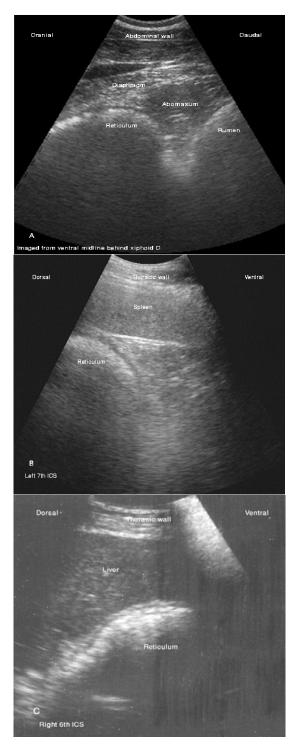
Sonogram of normal buffalo's reticulum with its relation to adjacent abdominal organs (rumen, abomasum, spleen, liver). Imaged from ventral midline of abdomen (A), left 7^{th} ICS (B) and right 6^{th} ICS (C). Notice the half moon shape of reticulum.
